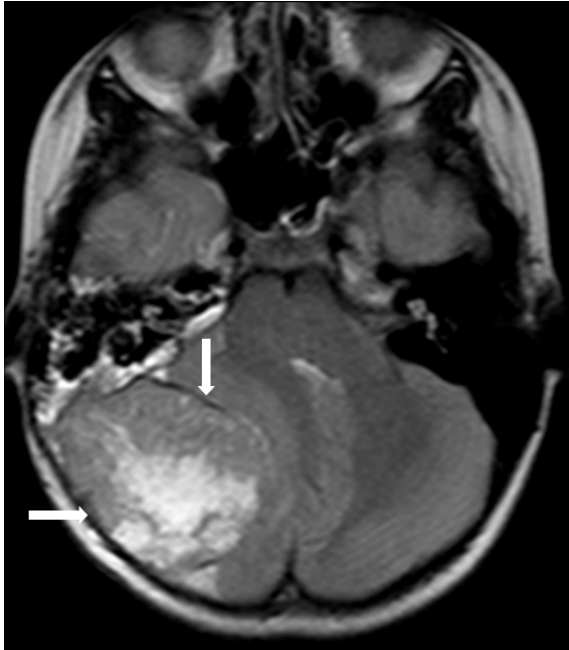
A T2 weighted axial MR image through the posterior fossa shows a dural-based right posterior fossa mass with heterogeneous signal intensity. The lesion also has cystic/necrotic areas. Displacement of right cerebellar hemisphere and brain stem with fourth ventricle compression were also present.
